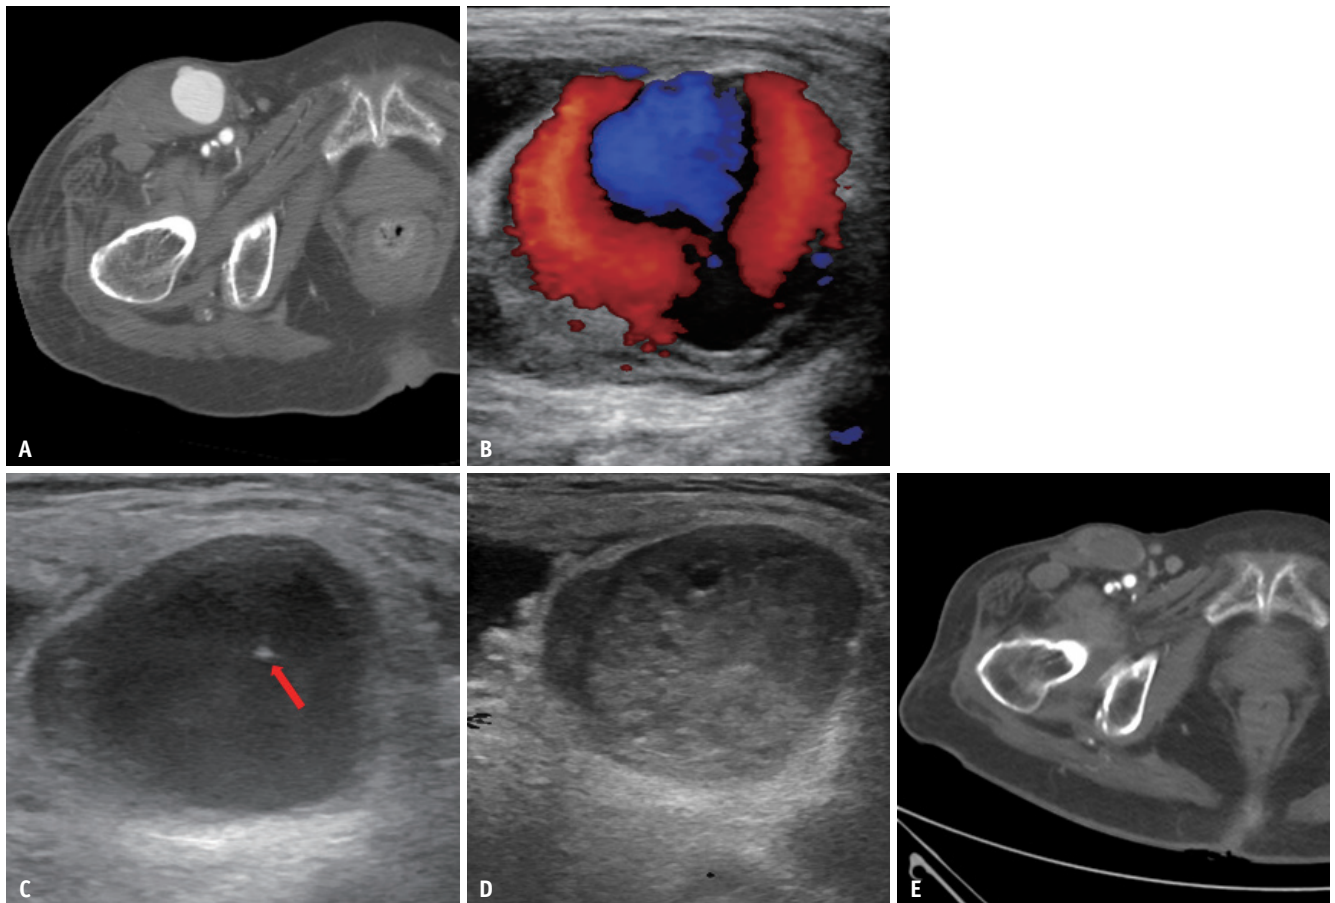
CT scan and ultrasonography images of a 75-year-old female undergoing percutaneous thrombin injection.
